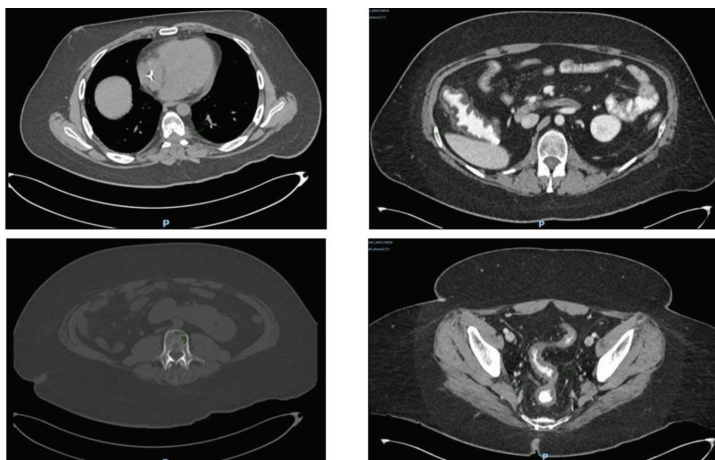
The abdominal CT scan showed bowel wall thickening
